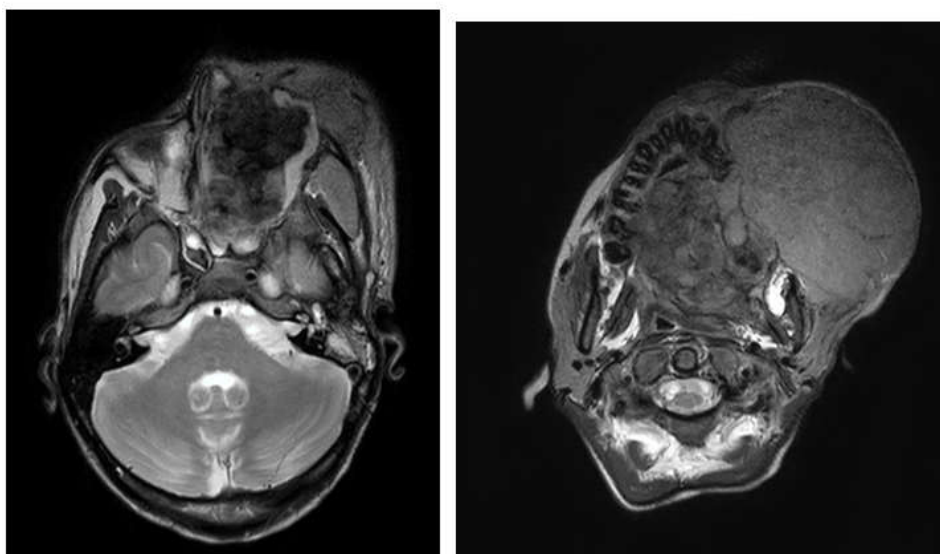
Axial MRI T2 sequence: heterogeneous hyperintense left jaw mass infiltrating the masseter and medial pterygoid muscles, invading the body of the tongue and the contralateral hemimandible
